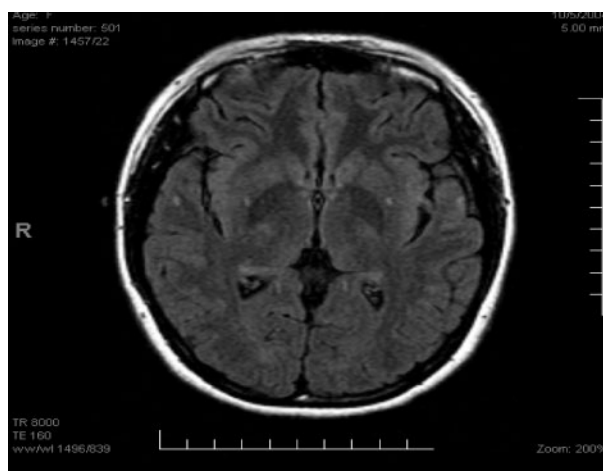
Fluid-attenuated inversion recovery (FLAIR) MRI image of the patient on 5 October 2004, showing no abnormality.
